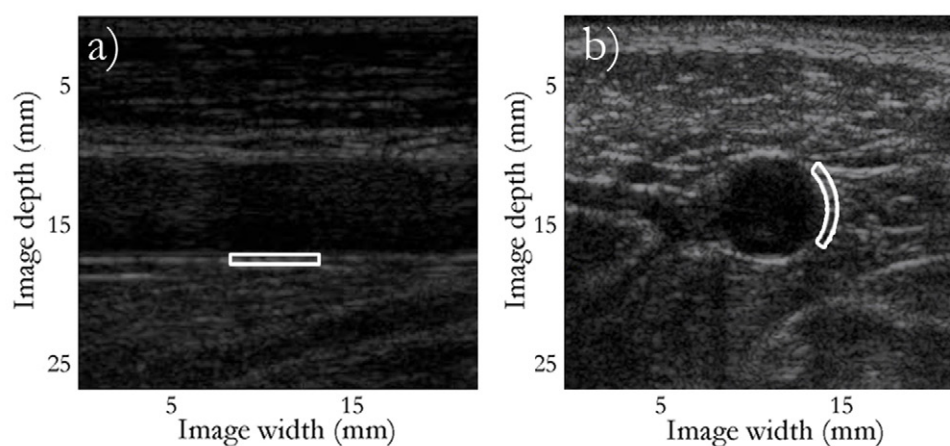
Ultrasound long-axis (a) and short-axis (b) images in end-diastole of the left common carotid artery. The white boxes represent the region of interest (ROI) for longitudinal strain (a) and circumferential strain (b). The ROI for radial strain estimation was positioned in the center of the ROI for longitudinal strain estimation. The images have been slightly zoomed for better visualization.
